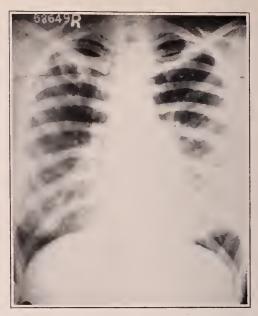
Case VI. Roentgenogram of Oct. 25, 1929, showing cavity in upper right lobe below clavicle (a).
